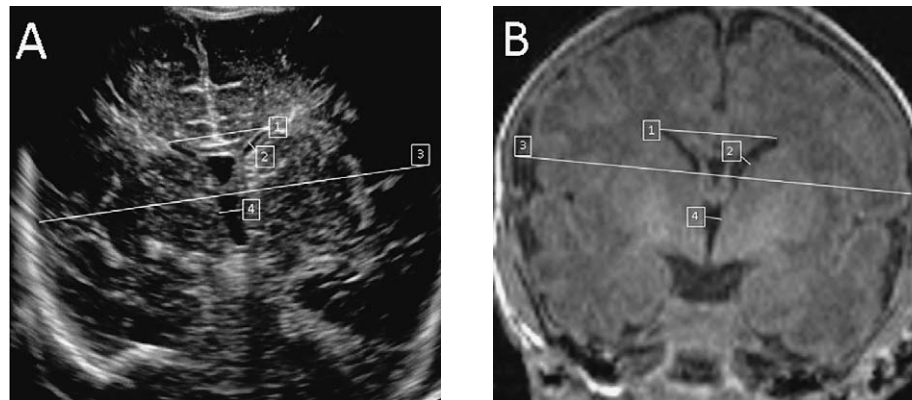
Measurement of the biventricular width (A, B-1), lateral ventricle (A, B-2), biparietal diameter (A, B-3), width of the 3rd ventricle (A, B-4) in the mid-coronal plane where the lateral and third ventricles were both seen on both coronal US (A) and MRI (B).
